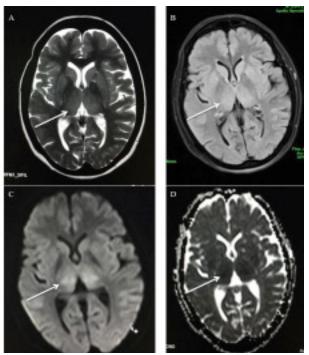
A-D: MRI Axial images showing bilateral symmetrical abnormal signals in thalami, which was hyperintense T2 and Flair not showing typical diffusion restriction on DWI and ADC.
